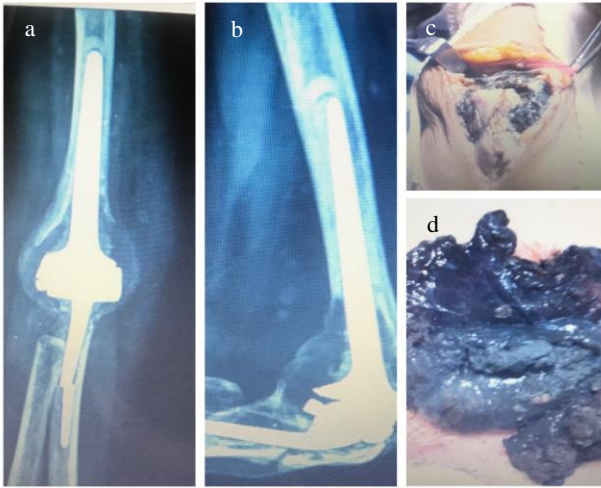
(a-d) Pre-operative X-ray right elbow and intraoperative picture right elbow.
